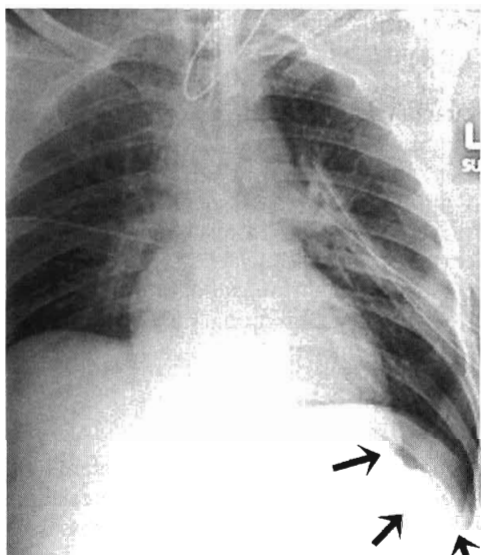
Bedside anteroposterior chest radiograph shows lucency without pulmonary vessels in the lower left lateral hemithorax expanding the costophrenic sulcus (*arrows*), despite two left thoracostomy tubes, consistent with pneumothorax, reflecting the deep sulcus sign.
